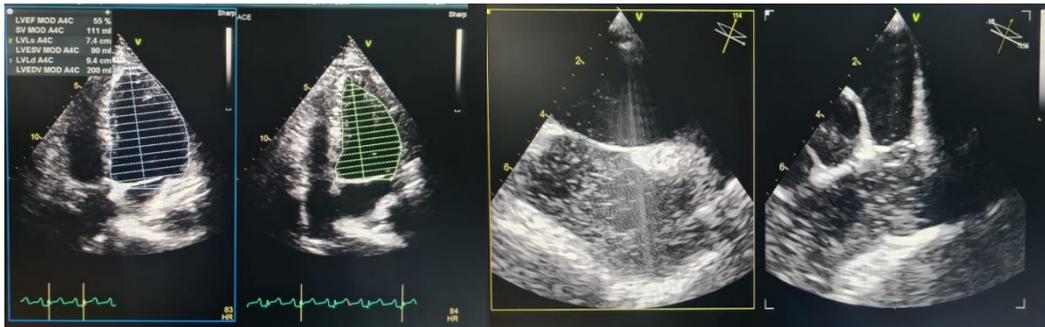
Transthoracic Echocardiography and Transesophageal Echocardiography with Bubble test
